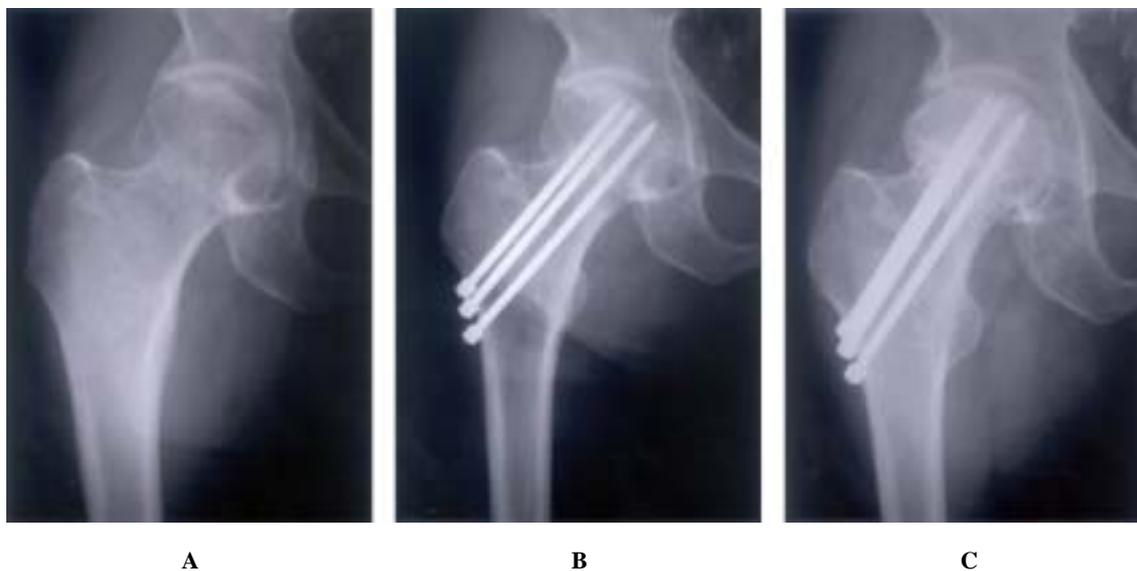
Preoperative radiograph of 73 years old male patient showing Rt. femur neck fracture of Garden stage 1.
